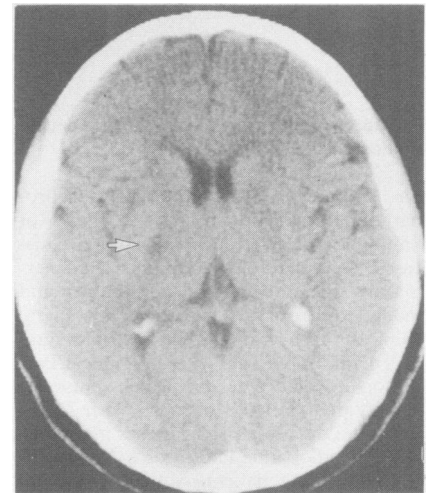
Fig CT scan showing infarction (arrowed) in the left internal capsule adjacent to the thalamus
